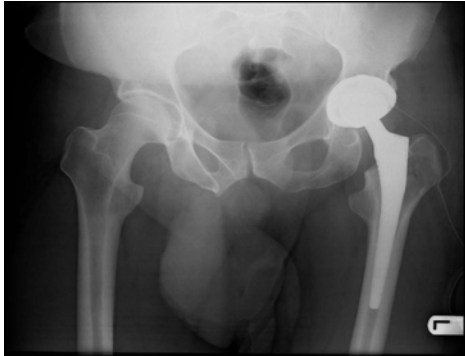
Post-operative radiograph of left un-cemented total Hip Arthroplasty.
